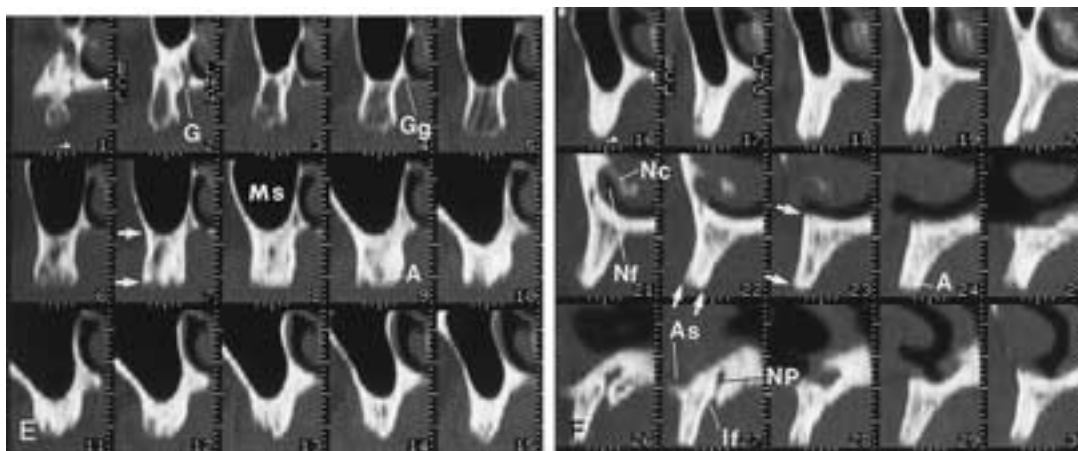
Continued.* E and F, Cross-sectional views. Images 1 through 15 (E) are through the posterior right maxilla (see perpendicular lines 1 through 15 in A); images 16 through 30 (F) are more anterior on the right and extend to the midline (see perpendicular lines 16 through 30 in A). The arrows in image 7 (E) indicate how the height of the distal alveolar process is measured from the floor of the maxillary sinus to the top of the alveolar process and the mesial alveolar process (F in image 23) is measured from the floor of the nasal fossa to the top of the alveolar process (arrows in image 23). The arrows in image 22 (F) indicate how the width of the alveolar process is measured. A indicates alveolar process; As, anterior maxillary spine; G, greater palatine foramen; Gg, groove for greater palatine nerve; If, incisive foramen; Ms, maxillary sinus; Nc, nasal concha; Nf, nasal fossa; and Np, nasopalatine canal. (From Abrahams JJ. Anatomy of the jaw revisited with a dental CT software program: pictorial essay. *AJNR* 1993;14:979–990.)
